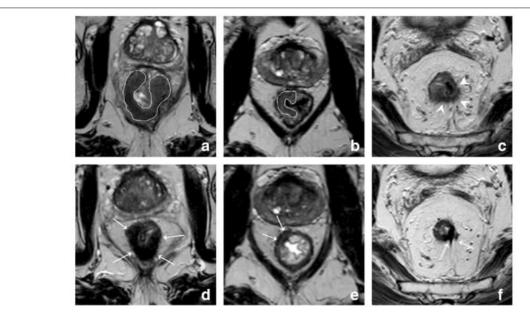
MR images showing different fibrosis grading[9]
